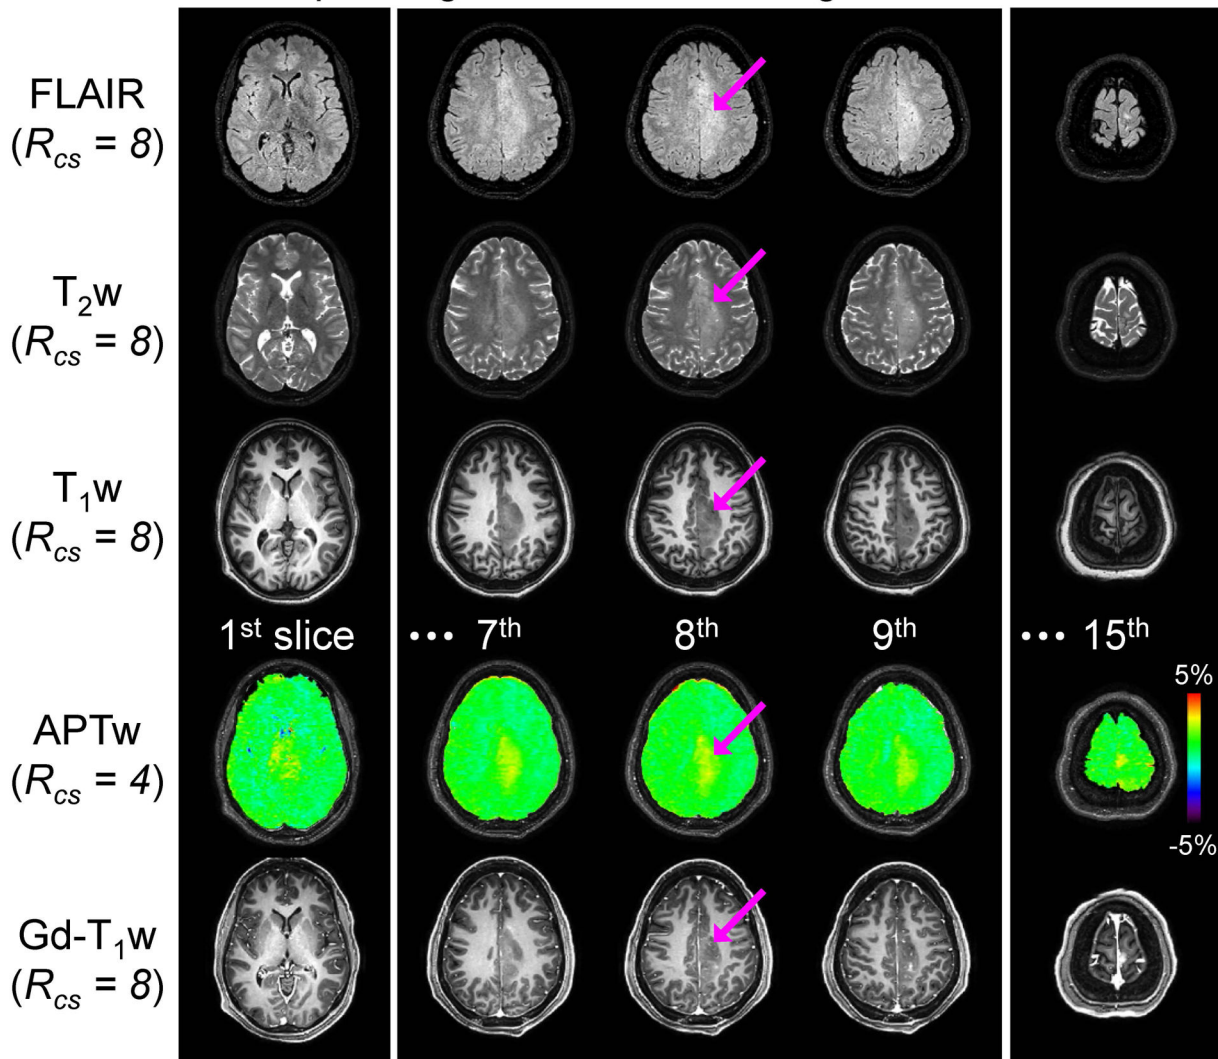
Conventional MR images and APTw images for a representative patient with an anaplastic oligodendroglioma. Five out of a total of fifteen APTw image slices are shown together with corresponding FLAIR, T_2w , T_1w , and Gd- T_1w images. The grade III lesion was slightly enhanced on the post-contrast images and also showed an intermediate APTw signal.
